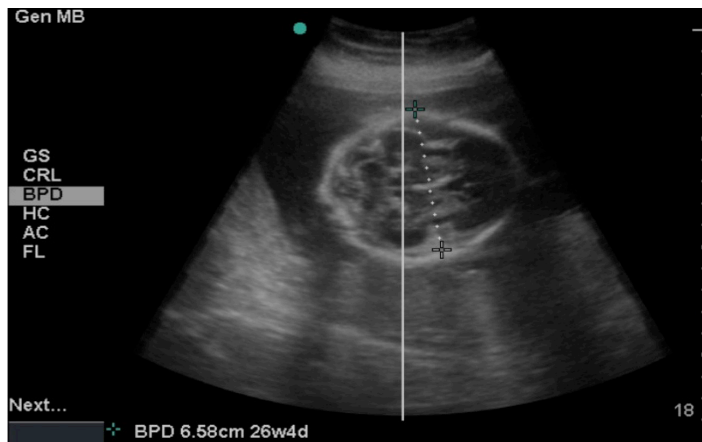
Emergent point-of-care transabdominal ultrasound demonstrated a biparietal diameter of 6.58 centimeters - consistent with a fetal gestation of 26 weeks 4 days. Based on the patient's reported gestational age, the fetal gestation should have been 24 weeks 5 days. This discrepancy raised concern for fetal intracranial injury.
